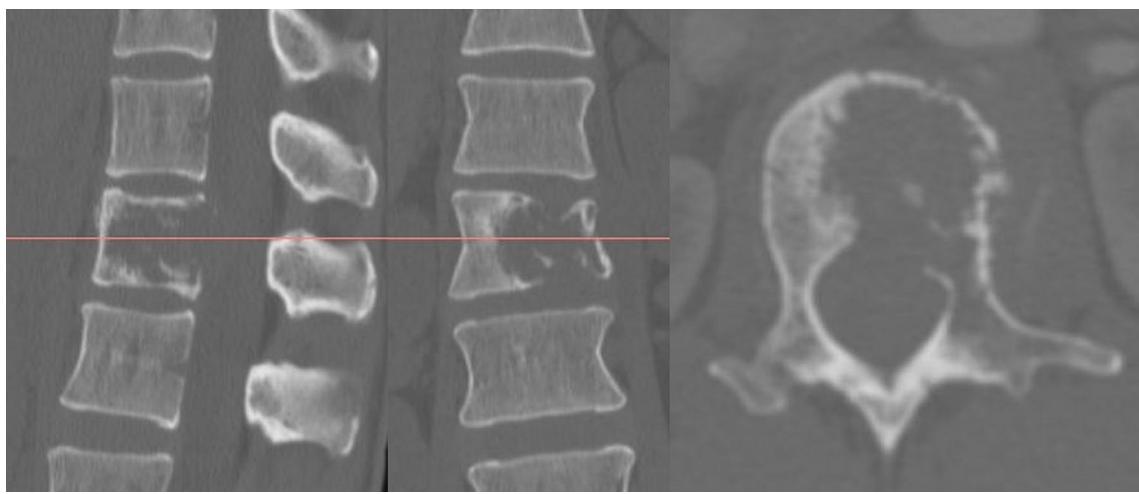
Preoperative computed tomography images of the lumbar spine. Computed tomography image revealed osteolytic tumor involving the L1 vertebral body
